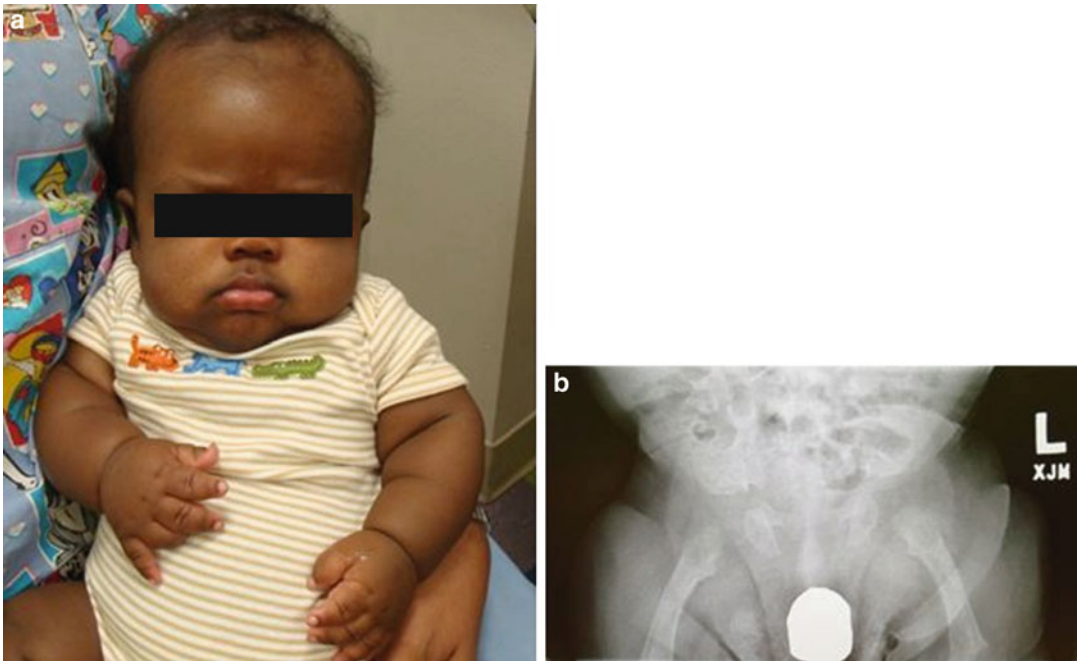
This 4-month-old boy had typical clinical (a) and radiographic (b) features of achondroplasia. Molecular testings indicated the presence of a G>A transition at nucleotide 1138 (c.1138G>A) of the fibroblast growth
